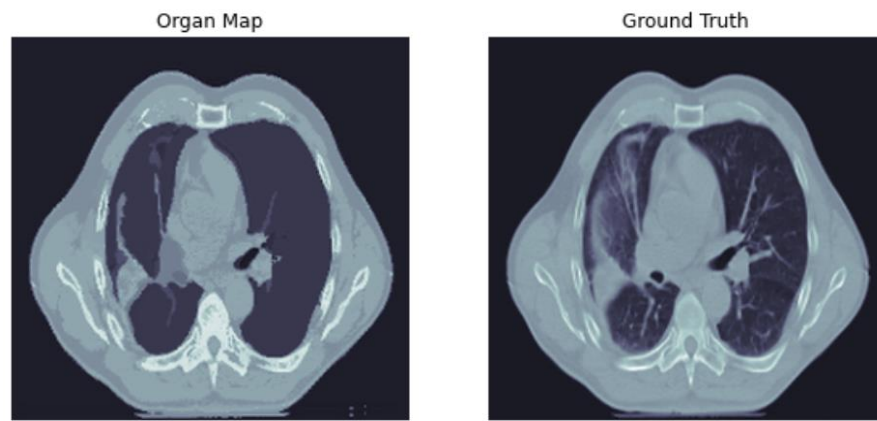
A sample pair with an organ map (left) and its CT image (right)
